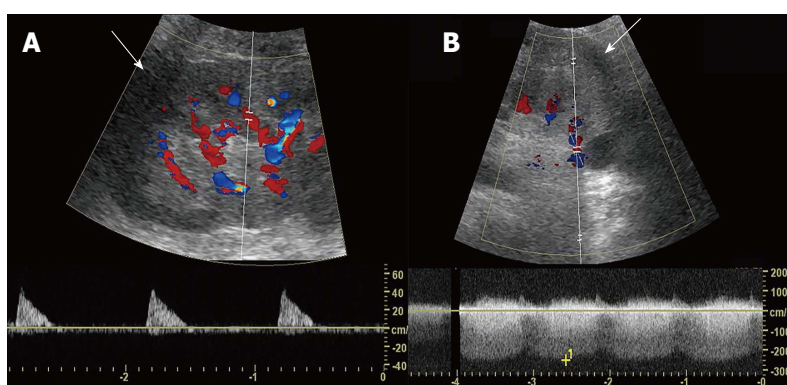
Presence of peri-allograft hematoma and Doppler ultrasound findings. A: Transplant arterial flow. Peri-allograft hypoechoic area (arrows) with absent diastolic flow in the arcuate arteries; B: Transplant venous flow. The transplant renal vein was patent.
